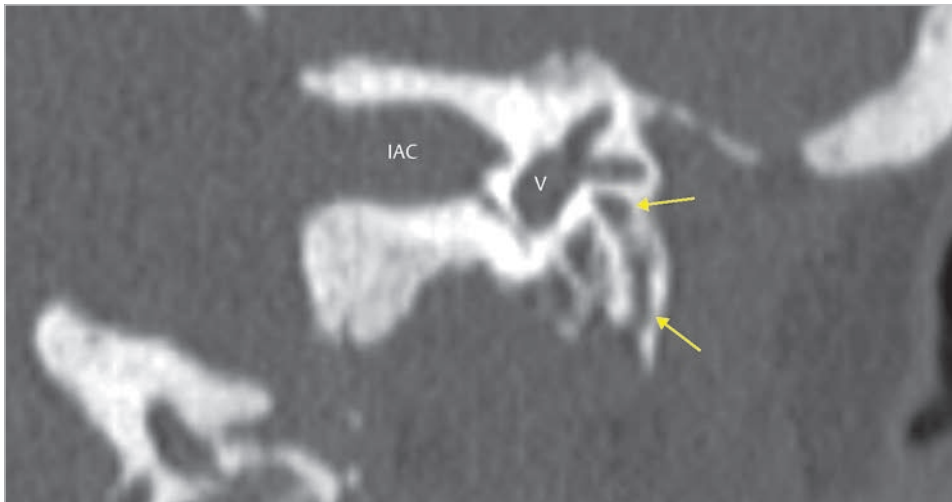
The postoperative CT in coronal section shows wide access to the hypotympanic area. The skeletonized facial nerve passing under the lateral semicircular canal is indicated by arrows. IAC, internal auditory canal; V, vestibule.
